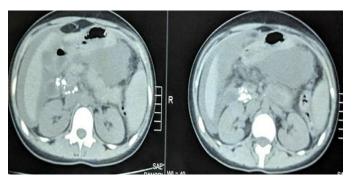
Plain CT abdomen shows ascites and lesser sac collection, calcification in the pancreatic head.
